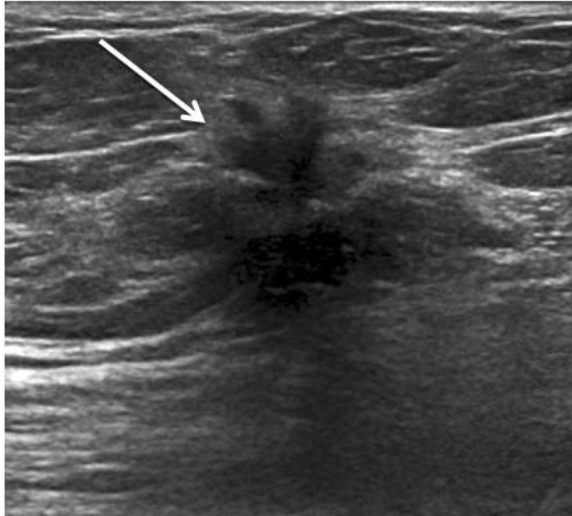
Automated breast ultrasound (top) and semi-automated ultrasound (bottom).
